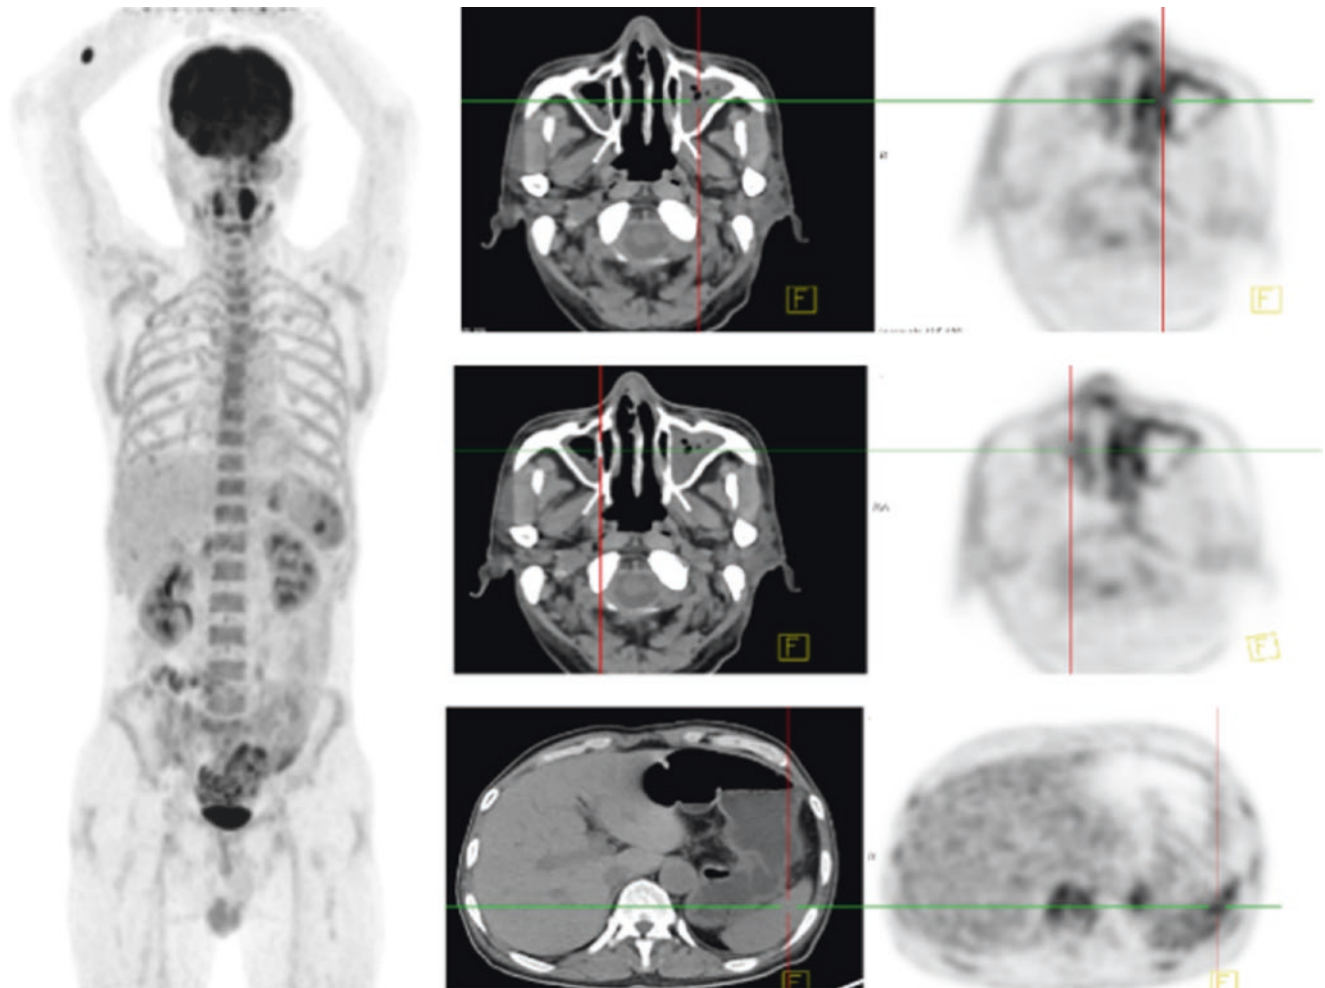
^{18}F -FDG PET/CT image
